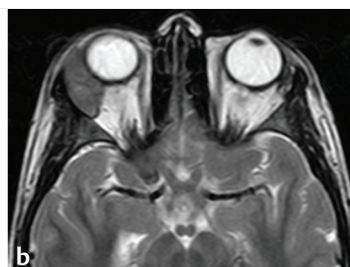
(a) Leukemic infiltrate of the right lacrimal gland causing mechanical ptosis of the right upper eyelid with an S-shaped configuration to the eyelid. (b) Axial cut of the orbital magnetic resonance imaging (MRI) show significant enlargement of the right lacrimal gland.
